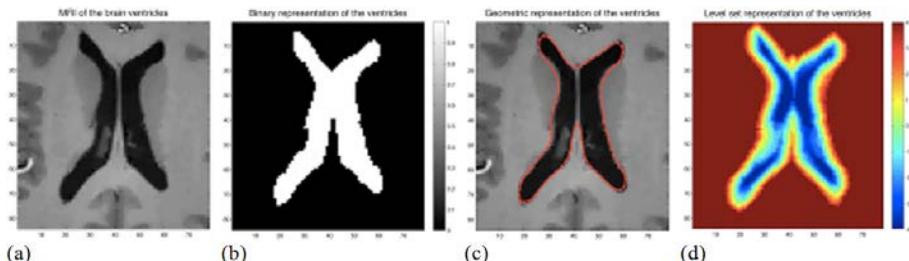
(a) An axial slice from a brain MRI; (b) binary; (c) geometric; (d) level set representations of the lateral ventricles in this image.
